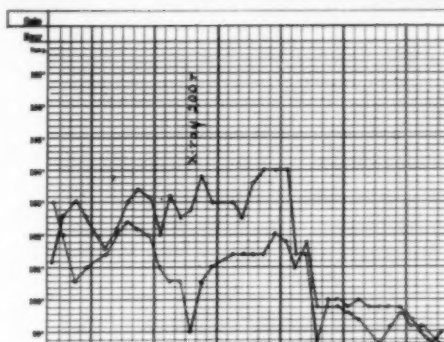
Lobar pneumonia of right upper lobe, treated two days before admission and two days after admission with a sulfonamide. No response noted. On third hospital day, 200 roentgens to right anterior chest, followed within 24 hours by clinical improvement and rapid lysis. Complete recovery.
